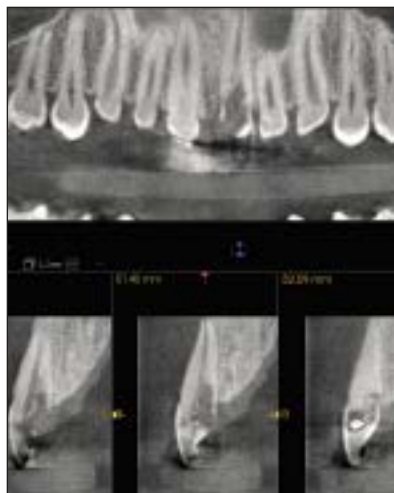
CBCT cross sections revealed significant loss of tooth structure consistent with invasive cervical root resorption. Note the limited thickness of the buccal plate. Extraction of the tooth would lead to a socket with unfavorable regenerative potential that presents a contraindication for conventional immediate implant placement.
